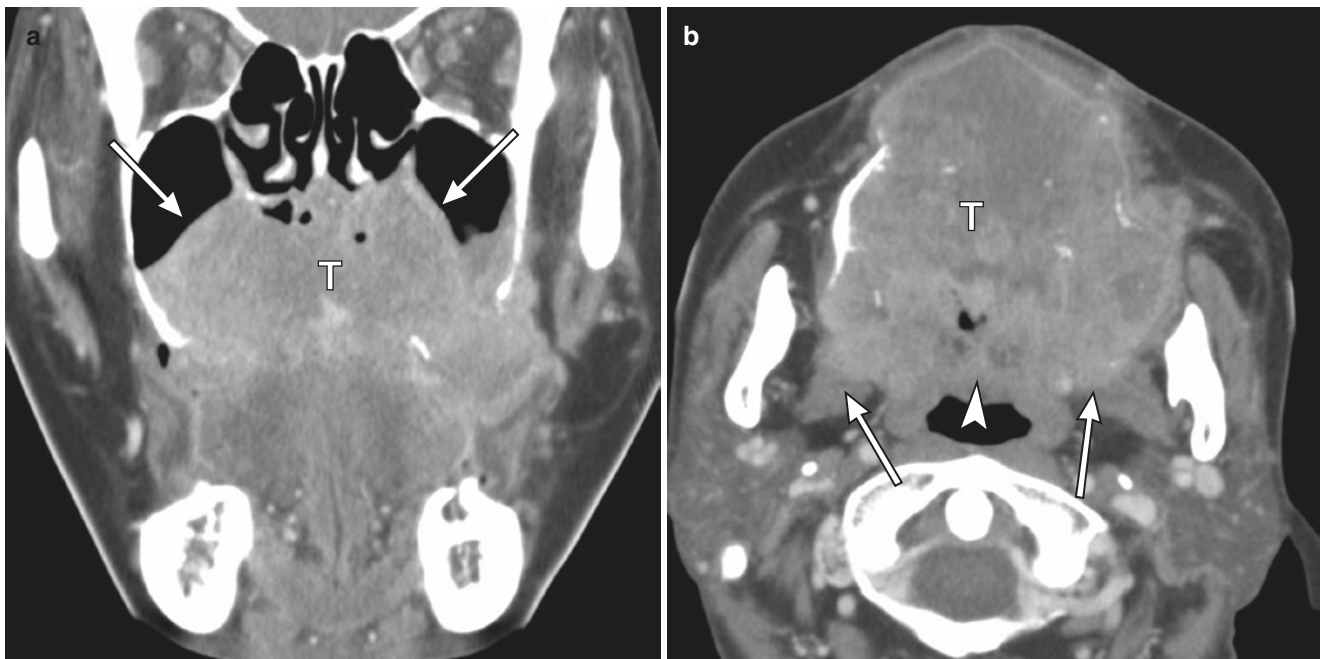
A 57-year-old woman with squamous cell carcinoma of the hard plate. (a) Coronal contrast-enhanced CT shows the tumor (T) invading the bilateral nasal cavity and maxillary sinus superiorly (arrow). (b) Axial contrast-enhanced CT shows that the tumor (T)
